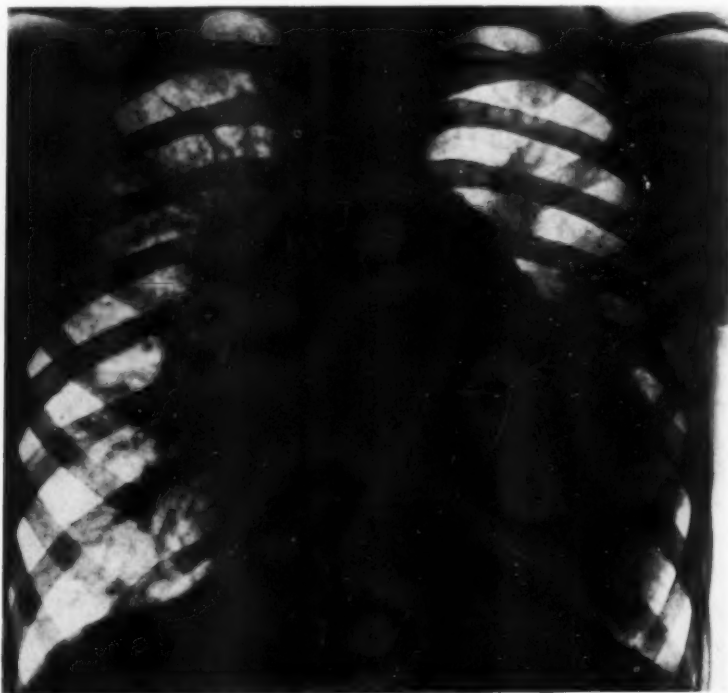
Roentgenogram of I. B. The heart is enlarged to the right and left with rounding of the apex and broadening of the waist. The pulmonary artery segment is prominent; the hilar branches are enlarged. The aortic arch is small.
